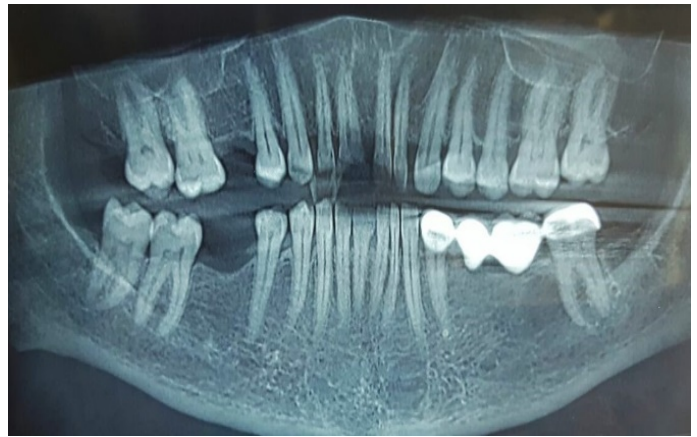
Orthopantomogramm
